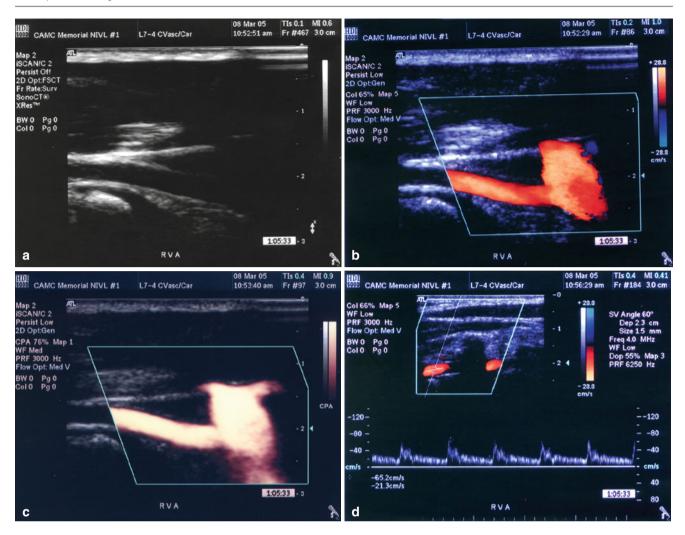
(a) Origin of right vertebral artery in gray scale. (b) Origin of right vertebral artery using color duplex ultrasound. (c) Origin of right vertebral artery using power Doppler. (d) Mid right vertebral artery (series of H appearance)
